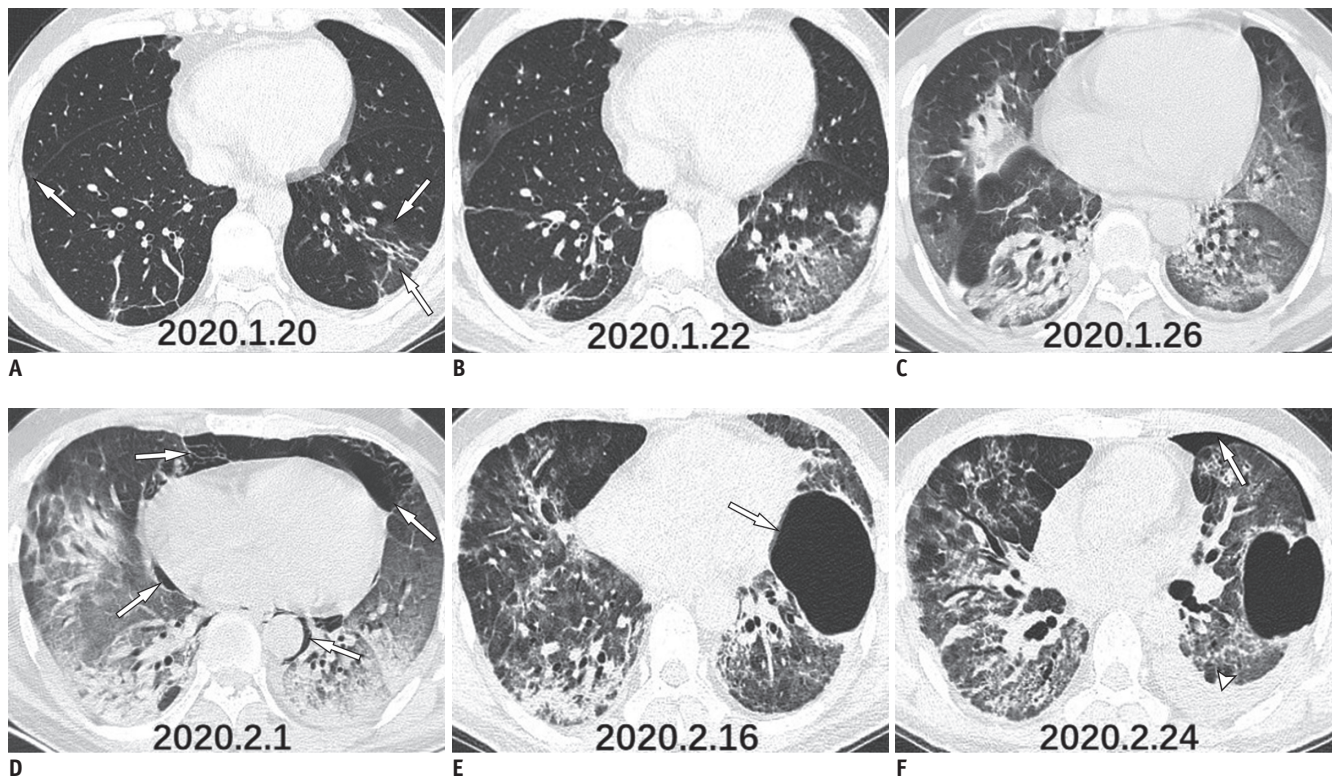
CT scans of 38-year-old man who presented with fever.
